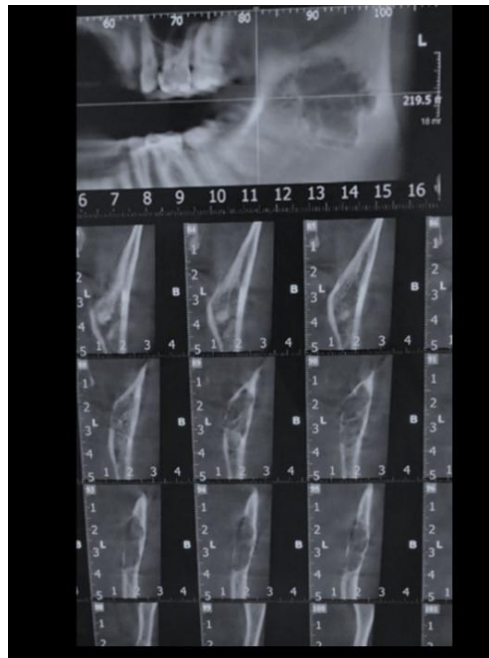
Computed tomography showing the fenestration on lingual and buccal surfaces.
